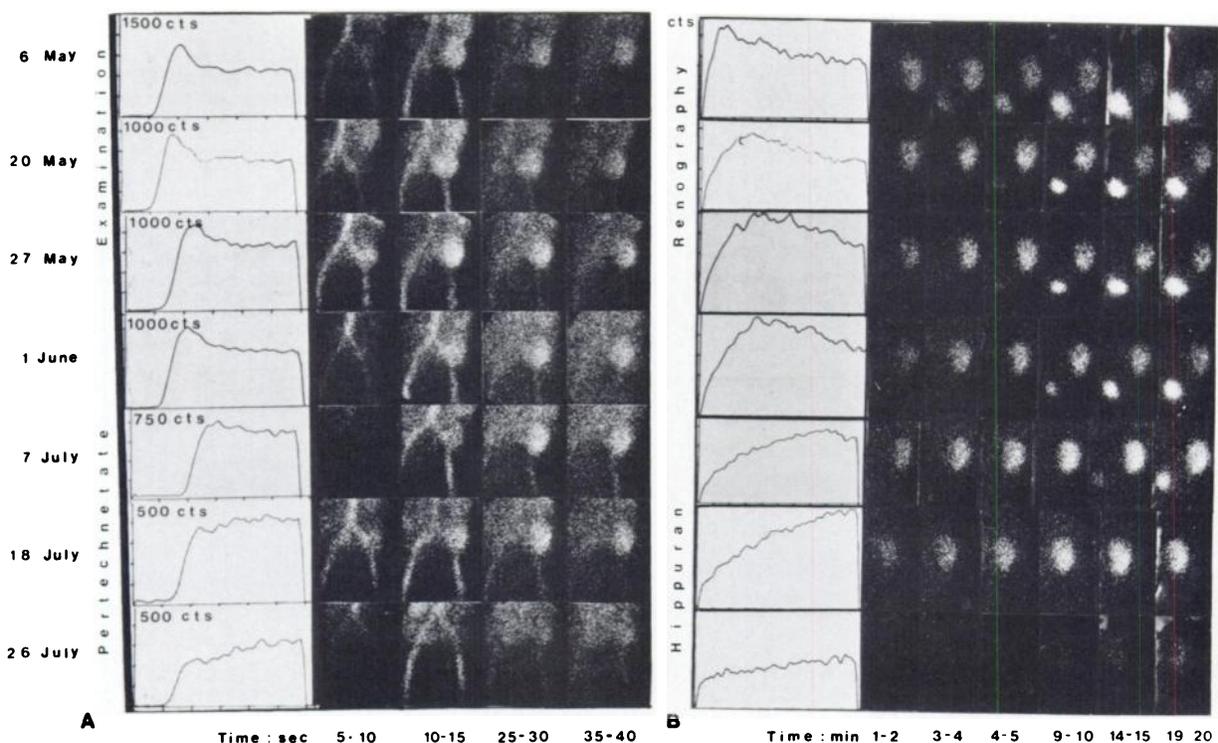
(A) Sequence of perfusion scintigrams documents change in perfusion pattern during destruction of graft due to stenosis of renal artery. (B) Hippuran sequence scintiphotos and renogram curves also document destruction of graft.
